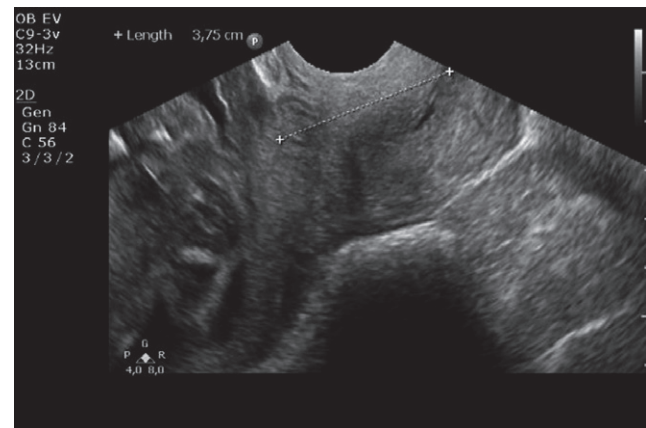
Ultrasound image demonstrating incorrect cervical-length measurement. The endocervical mucosa is not completely visible and the internal and external ora are not visible because the ultrasonographic plane is not completely midsagittal, resulting in incorrect caliper placement.
